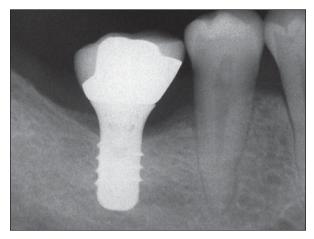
Periapical radiograph of an 8-mm-long wide-neck implant supporting a single posterior tooth, obtained 36 months following prosthetic restoration and 40 months after implantation.
